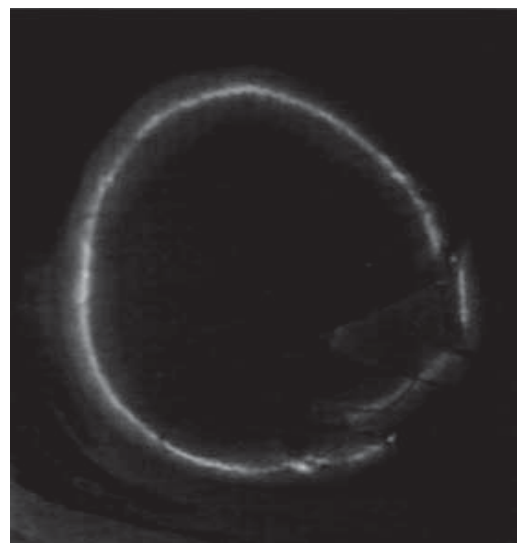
Computed tomography (bone window) of a patient with severe head injury with a left parietal impression fracture.
